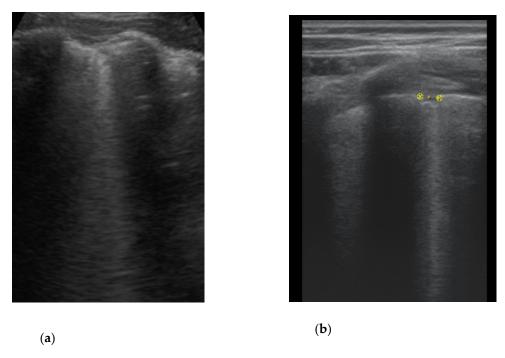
(a); (b) The lung ultrasound showed a small consolidation area with the length < 1 cm and with associated pleural abnormalities corresponding to a LUSS=2
